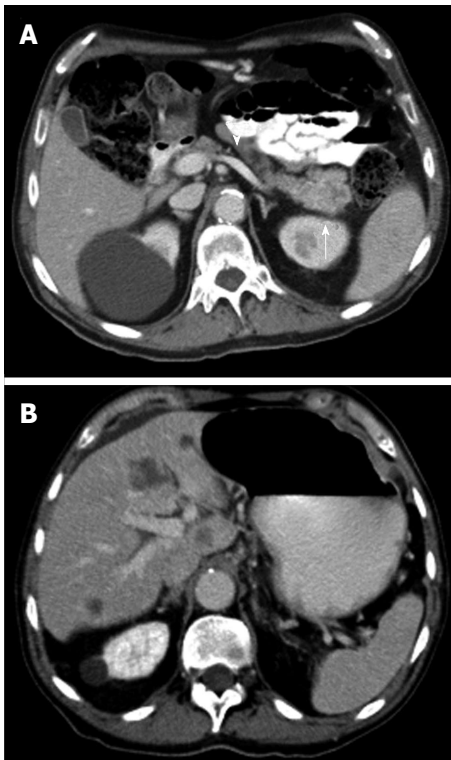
Axial contrast enhanced multidetector computed tomography image. Arterial phase imaging allows optimal visualization of the pancreatic neoplasm and peripancreatic arteries: the shown hypodense mass compromises the splenic artery (arrow). Pancreatic adenocarcinoma was proven by biopsy.
